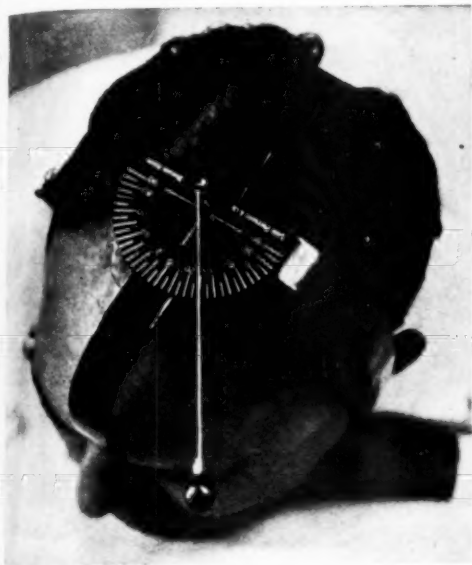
(Argañaraz). Plumb line on author's device indicates 38 degree lateral tilt of the head to bring axis of the optic canal into a plane perpendicular to the radiographic plate.
